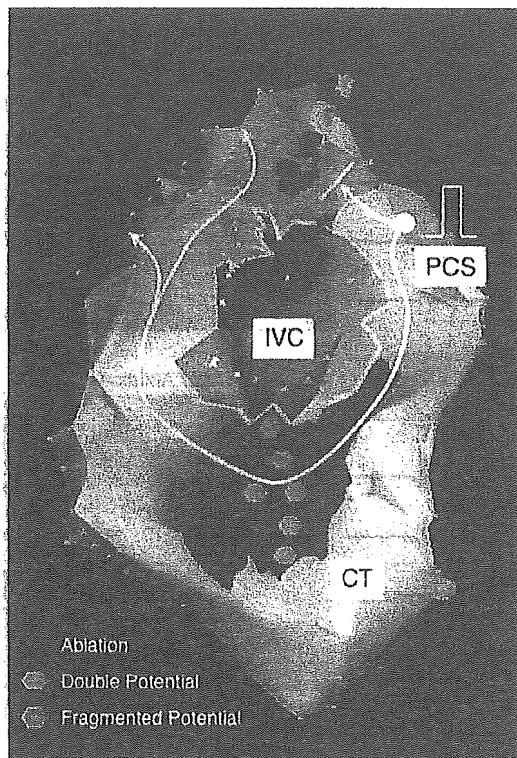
The CARTO remap during proximal CS pacing, viewed from the bottom, in the same patient as in Fig. 4. Mapping around the IVC orifice revealed the earlier wavefronts conducting transversally across the lower CT (red region). The double potentials (blue tags) were recorded at the middle part of the presumed site of the CT and the fragmented potentials (pink tags) were recorded at the lower part of the CT, suggesting the transversal conduction across the lower CT. CT: crista terminalis; IVC: inferior vena cava; PCS: proximal coronary sinus.
